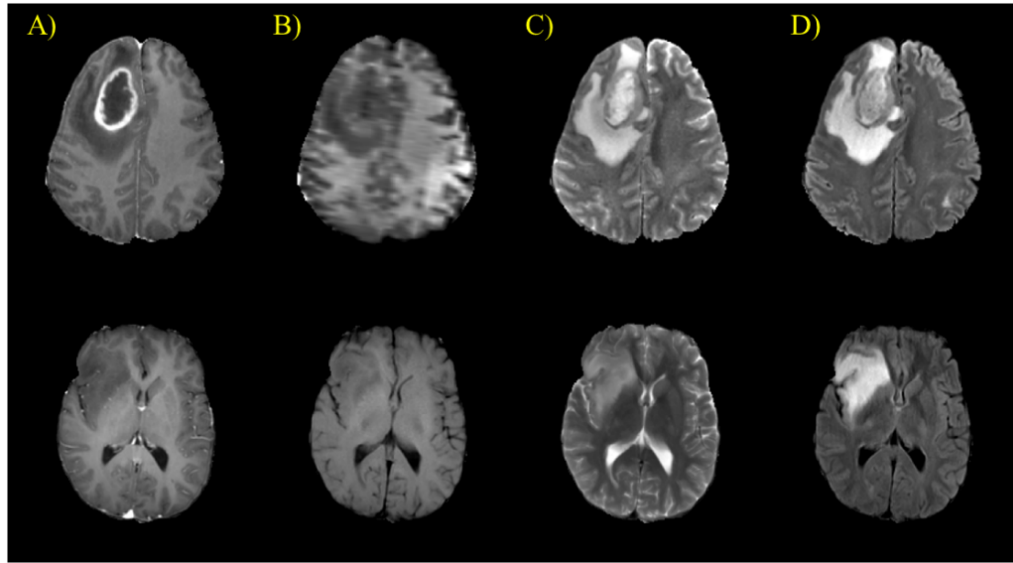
Different MRI sequences are examined to identify different brain tumor subregions: A) T1 gadolinium enhancement sequence; B) T1-sequence; C) T2-sequence; and D) FLAIR sequence. High-grade gliomas (first row) and low-grade gliomas (second row) appear with significantly different characteristics.
